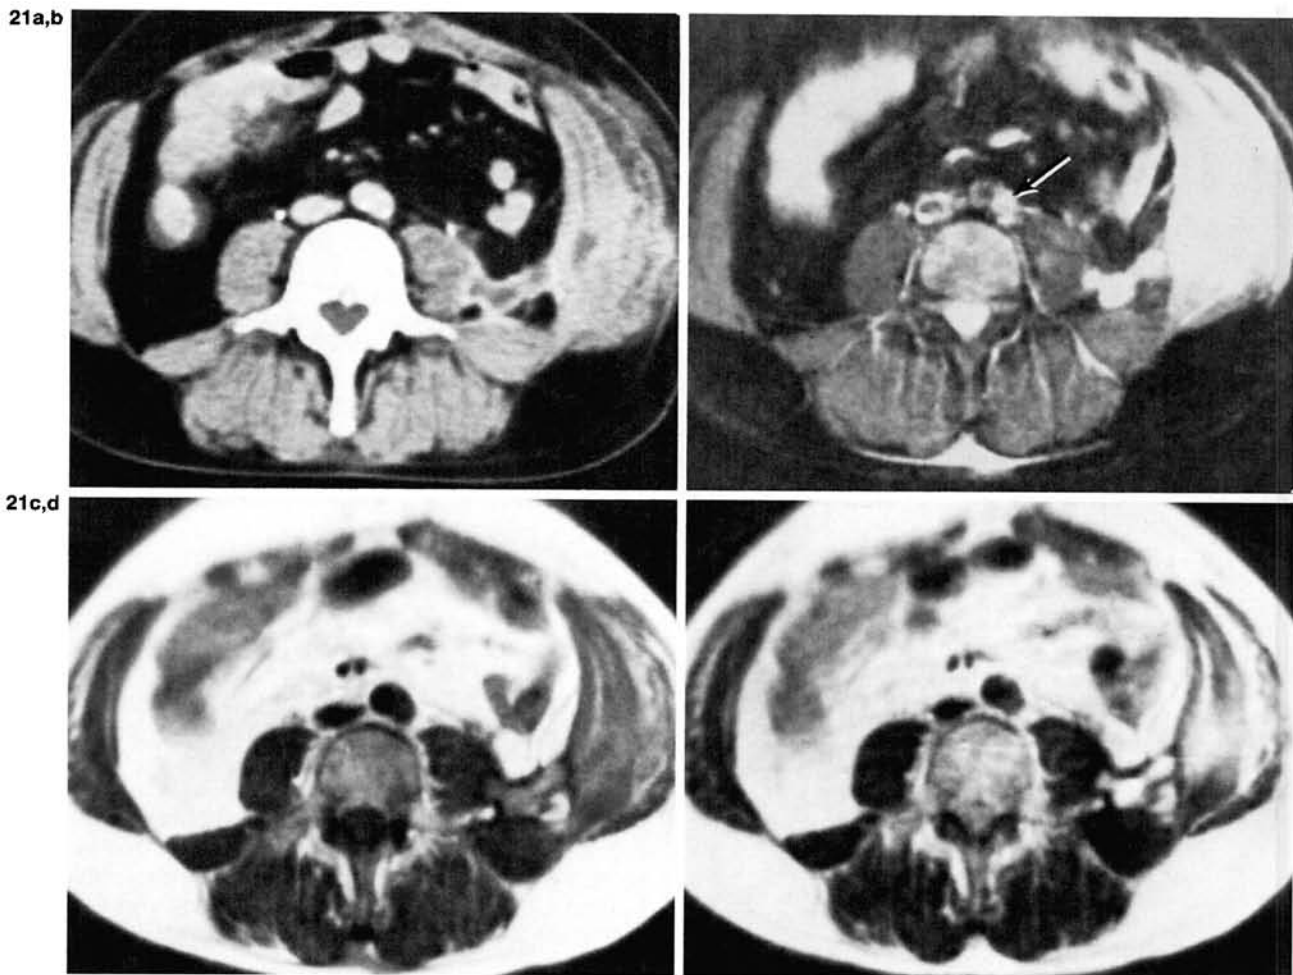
Psoas abscess: contrast enhanced CT (a), inversion recovery (IR)_{1,000/100/44} (b), spin echo (SE)_{544/44} (c), and spin echo (SE)_{1,500/80} (d) scans. Changes to the abdominal wall and the fluid tracking posteriorly are best shown in (b) as is the paraaortic lymph node (arrow).
